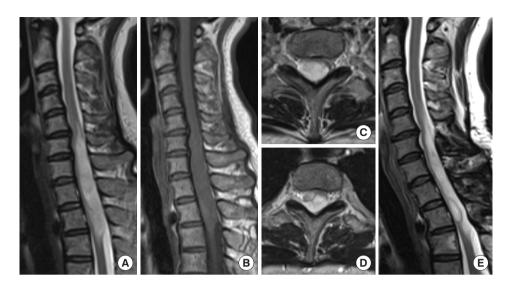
Diffuse astrocytoma, World Health Organization grade 2, *IDH1* R132H mutant. A 42-year-old woman experienced numbness in both lower extremities for about 3 years and numbness in the right upper extremity and muscle weakness in the right lower extremity for 2 months. Magnetic resonance imaging (MRI) revealed an intramedullary spinal tumor at the C5–T3 levels. The tumor diffusely expanded with high signal intensity on T2-weighted MRI (A, C, D) and without any enhancements on gadolinium-enhanced T1-weighted MRI (B). It was difficult to identify a distinct surgical plane for the tumor, and partial removal was achieved. The tumor was diagnosed as diffuse astrocytoma, *IDH1* R132H mutant. Forty-two months later, MRI showed no evidence of tumor growth (E), and her symptoms were stable.
